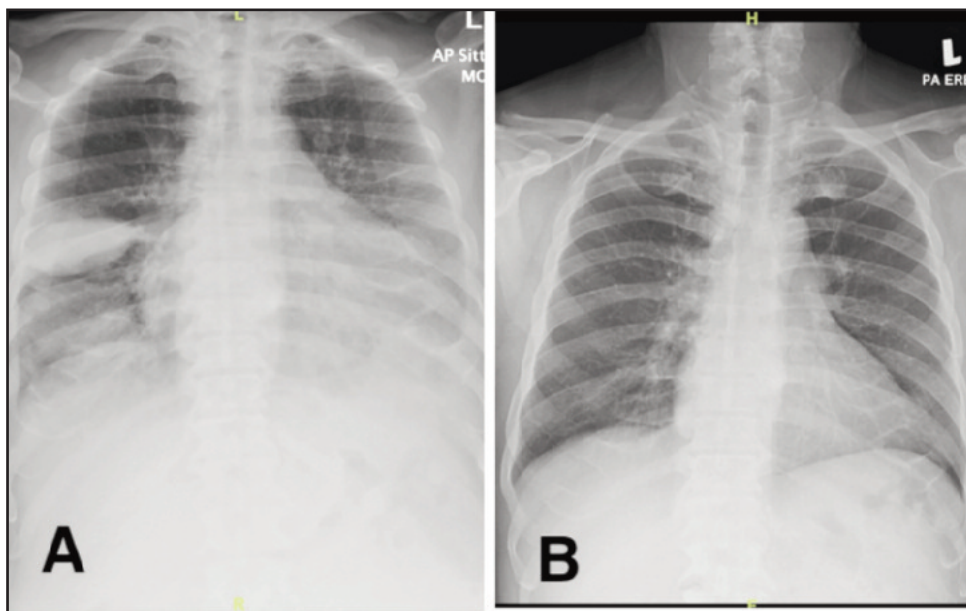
Panel A shows a well define semi-rounded mass with bilateral lower zone homogenous opacities and blunted costophrenic angles. Panel B shows an x-ray of the same patient taken 10-day apart, which shows a complete resolution of the changes described in panel A.
